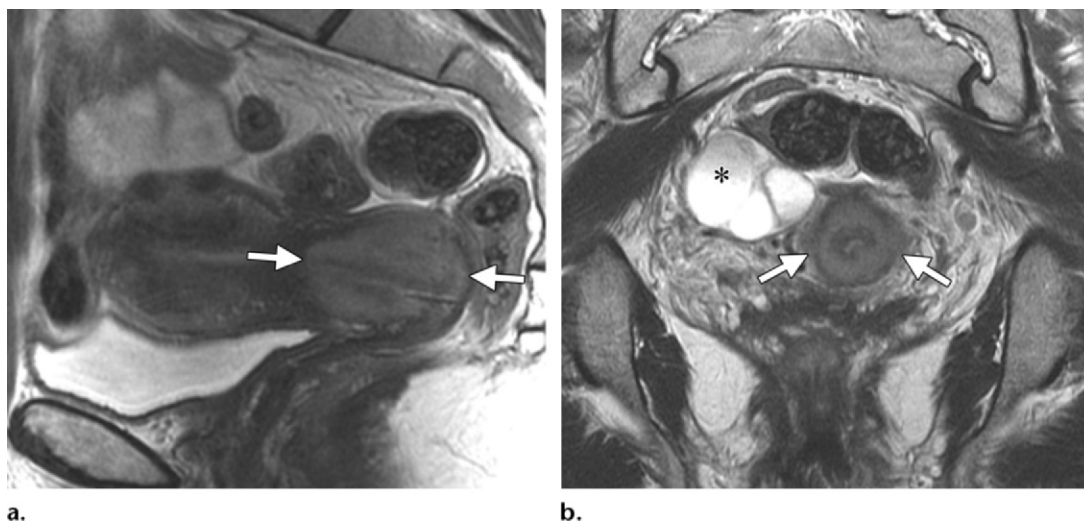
Stage IIB cervical carcinoma (adenocarcinoma) in a 48-year-old woman. (a) Sagittal T2-weighted MR image shows a tumor (arrows) with intermediate signal intensity replacing the normal low-signal-intensity cervical stroma. (b) Axial oblique T2-weighted MR image obtained perpendicular to the endocervical canal shows interruption of the low-signal-intensity cervical stromal ring. Nodular soft tissue extends bilaterally into the parametrium (arrows), a finding indicative of parametrial invasion. Right hydrosalpinx (*) is also incidentally noted.
